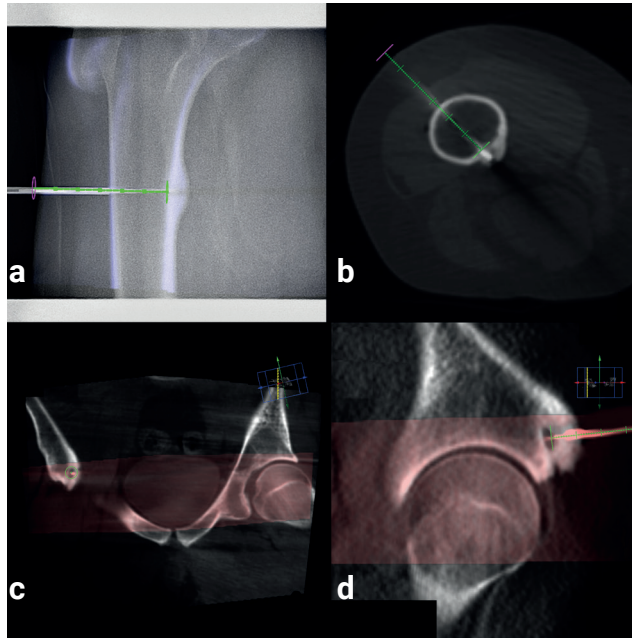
Cone-beam CT images of 2 patients with osteoid osteoma. a shows the overlay during fluoroscopy guidance in the progress view. b shows a cone-beam CT-scan of the same patient, with the RF electrode along the planned needle path (green). In c and d the cone-beam CT-scan is fused with a previous CT-scan, the CT-scan is visualized in grey and the cone-beam CT-scan in red. In c the entry point view is visualized and d shows the progress view.
